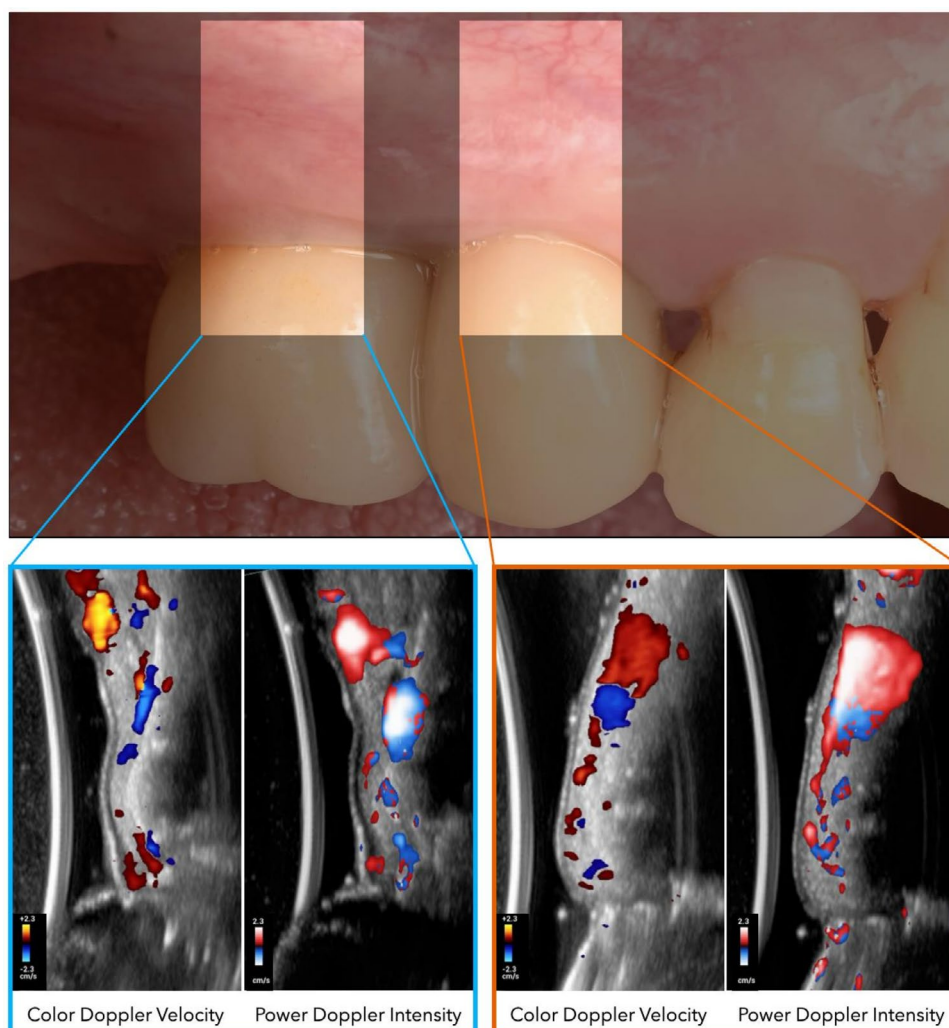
Color and power Doppler ultrasonographic assessment at the midfacial aspect of the implants.
